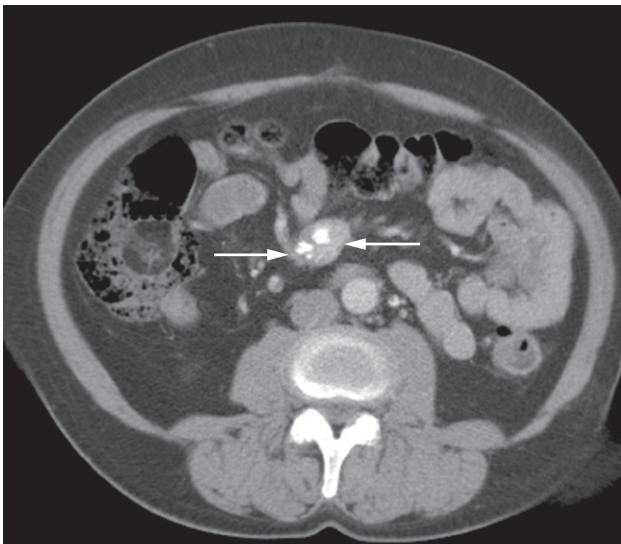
CT demonstrating a mass in the small bowel mesentery (arrows), which contains several dense calcifications. This is a secondary deposit from an ileal carcinoid tumour.
